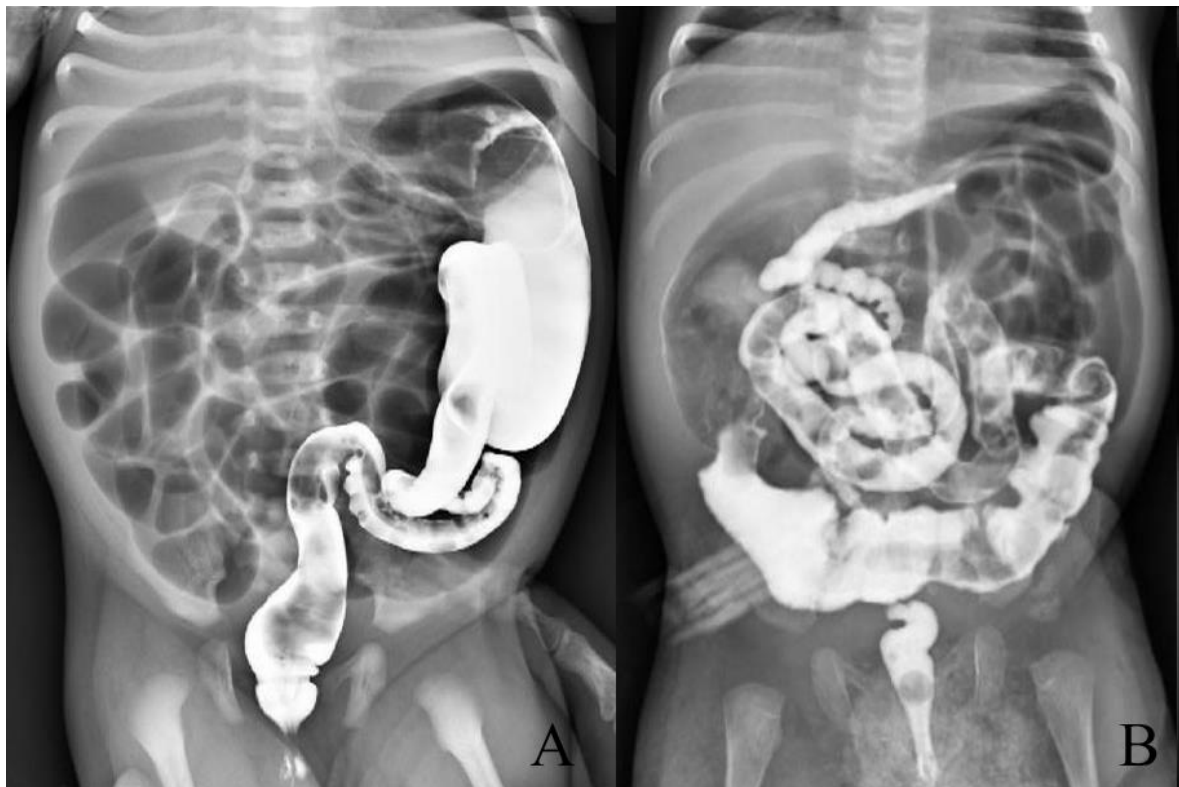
The plain abdominal X-ray after ultrasound-guided contrast enema show to reach the contrast media to dilated proximal loop; A) meconium pellets in small left colon syndrome. B) Narrow unused colon and terminal ileum contain meconium pellets in meconium ileus and reaching of contrast media to proximal dilated loop.
